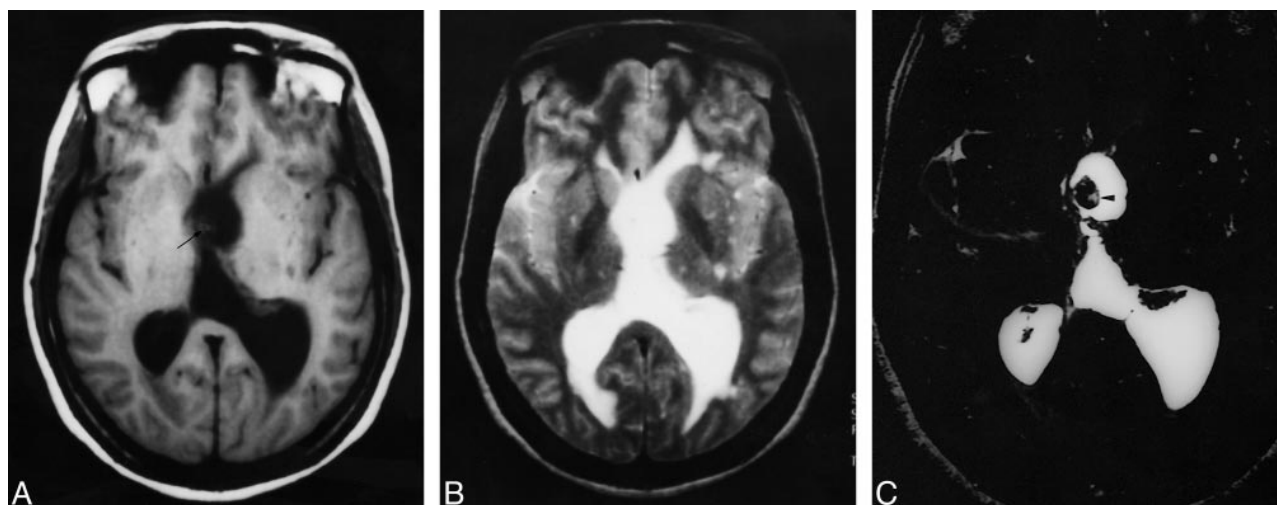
A, Axial T1-weighted (650/14/1) image shows dilatation of the left lateral ventricle with subtle isointense lesion noted in the region of the foramen of Monro (arrow).
